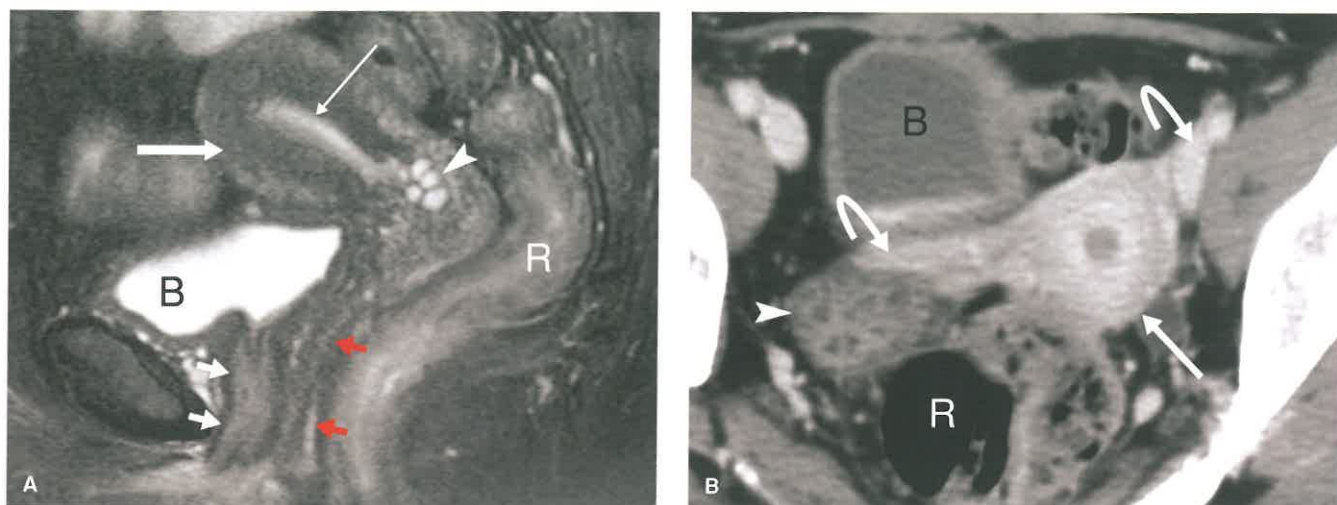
Normal Uterus. A: Sagittal T2-weighted MR image shows the uterus (*large arrow*), and the high signal intensity endometrium (*skinny arrow*) surrounded by the low signal intensity junctional zone myometrium. Multiple nabothian cysts (*arrowhead*) are present in the endocervical canal. The vagina (*short red arrows*) is shown as a low signal intensity muscular tube with the urethra (*short white arrows*) coursing in its anterior wall. High signal urine identifies the bladder (*B*) anteriorly. The rectum (*R*) is seen posteriorly. B: Axial postcontrast CT image shows the uterus (*arrow*) in transverse plane with enhancing endometrium surrounding a small volume of low attenuation fluid in the uterine cavity. The broad ligaments (*curved arrows*) enveloping the enhancing fallopian tubes and parametrial vessels extend laterally from the uterus to the right ovary (*arrowhead*). The bladder (*B*) containing low attenuation urine without contrast creates a fluid layer with high attenuation urine containing excreted contrast. The rectum (*R*) containing gas is seen posteriorly.
